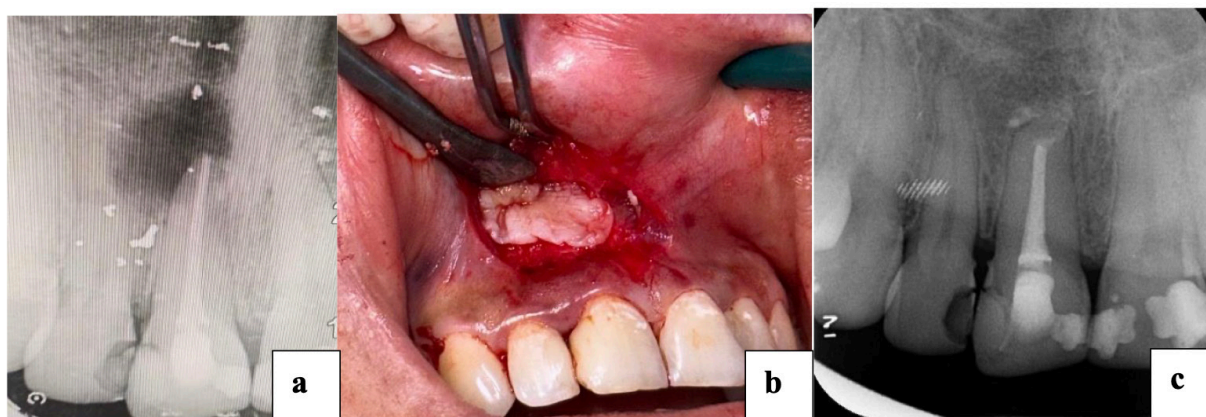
Preoperative periapical radiograph (a) shows the periapical lesion associated with tooth #11, intraoperative view during apical surgery (b) demonstrates the exposed root apex and the PRF membrane in the surgical field, and postoperative periapical radiograph (c) is the 6-month periapical radiograph in Case 2.
